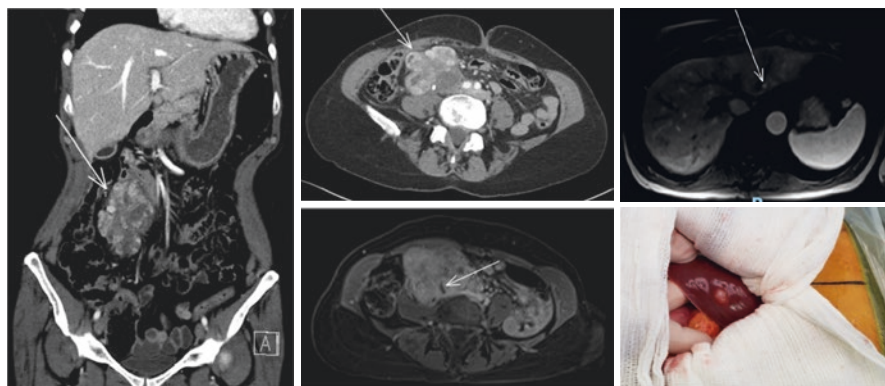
A 59-year-old female patient noticed an abdominal mass on self-examination. MRI showed a retroperitoneal mass with lobulated contours, with heterogeneous sign, exuberant vascularization, and areas of necrosis, in contact or originating in the inferior vena cava, with involvement of the right ureter and hydronephrosis. Note that the vena cava is not seen from the confluence of the common iliac veins up to the level of L3–L4. The patient underwent an image-guided biopsy and the pathological examination revealed a high-grade leiomyosarcoma. Neoadjuvant radiotherapy was performed, followed by surgery. During the operation, the presence of liver metastases was detected, which led to the interruption of the procedure (shown in the last photo). Two years after the date of the surgery, the patient is undergoing systemic treatment with stable disease
